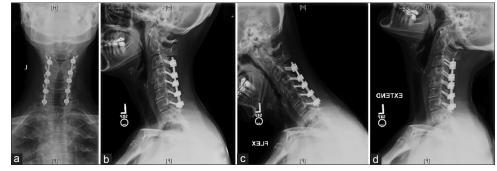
Same patient; postoperative X-rays: Image (a) AP; (b) neutral; (c) flexion; and (d) extension
